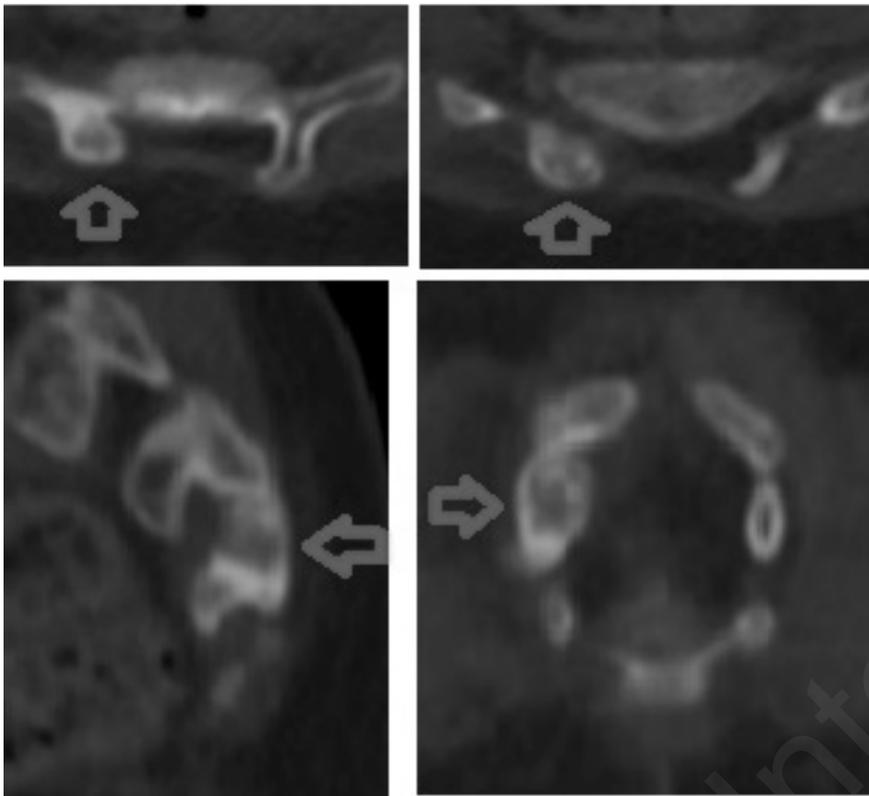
Sacral CT scan of right S4-level posteriorly located osteoid osteoma (axial, sagittal and coronal views).
